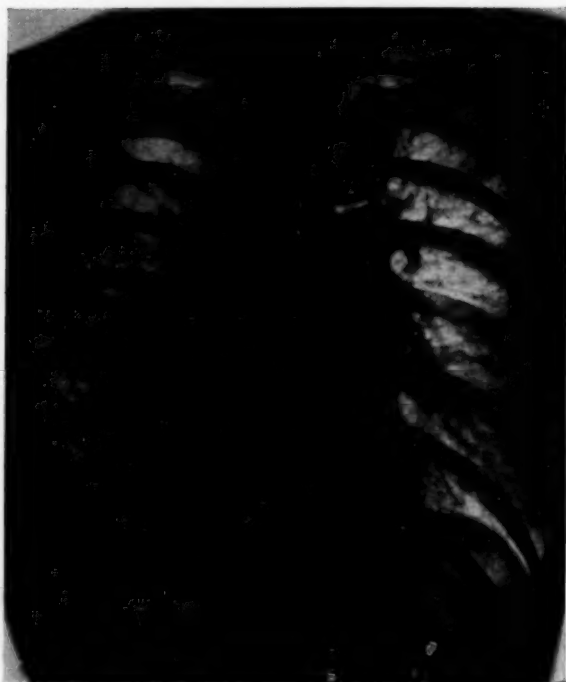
Posteroanterior chest radiography showing the features of slight dextrocardia with overdistention of the left lung and increased vascularization. A vascular shadow is clearly seen on the right side, parallel to the right auricular border.
